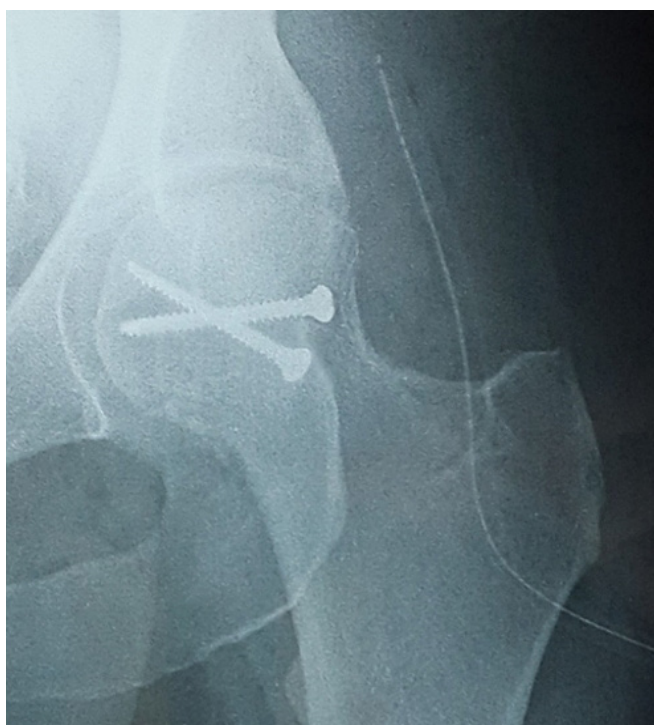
Postoperative anteroposterior x-ray demonstrating satisfactory anatomical reduction of the fractured femoral head fragment, which was secured with two screws.
